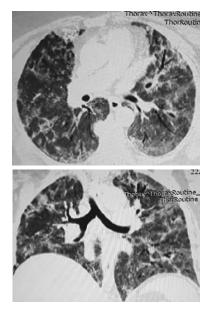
X-ray computed tomography scan by the end of the inpatient stage of treatment
